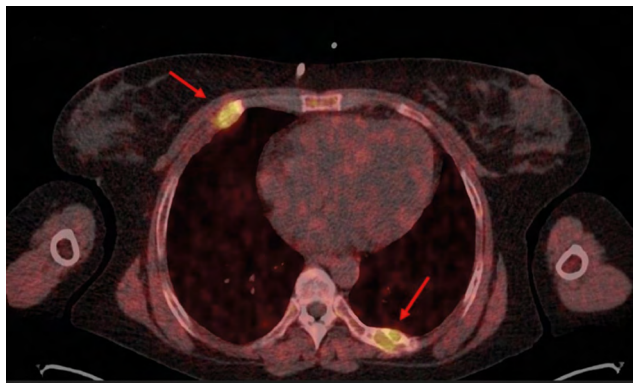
Intense focal choline accumulation in osteolytic rib bone lesions (arrows) (SUV_{max} 8.6 and 10.3) corresponded to brown tumours — fibrous osteitis cystica
